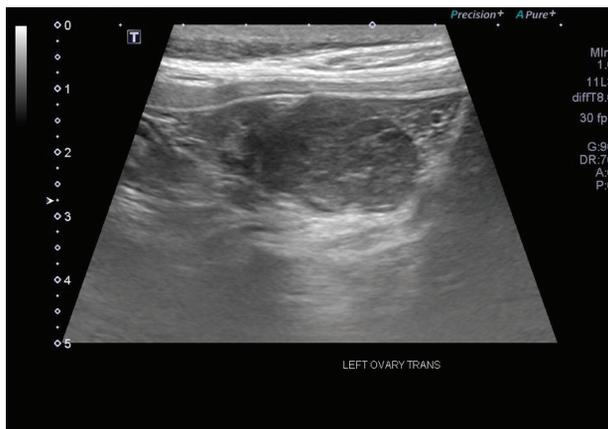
Ultrasonographic image of ‘abnormal’ left ovary on day 57 of estrus (note: honeycomb-like appearance suggestive of early stages of differentiation of a GCT)
